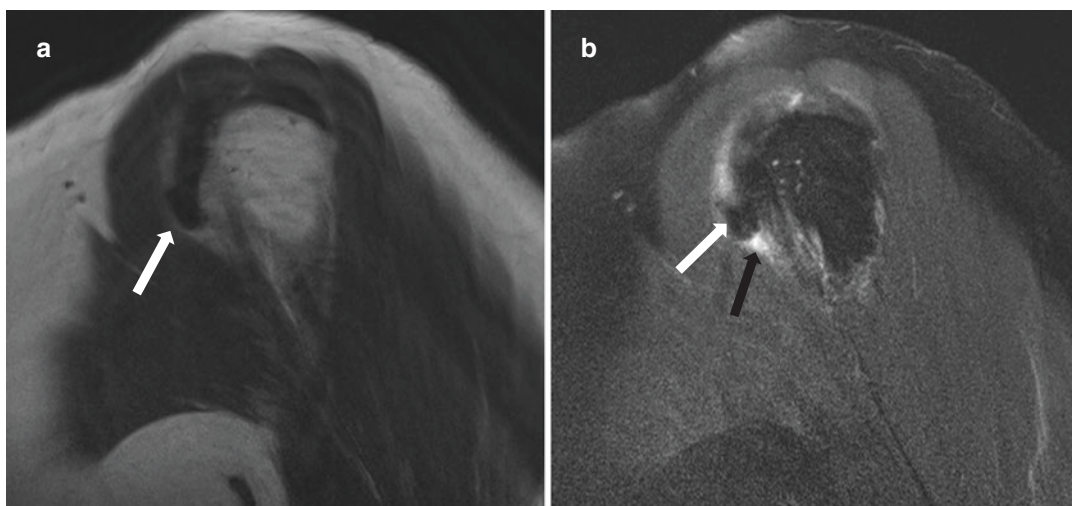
Calcific tendinitis. Sagittal oblique proton density (a) and sagittal oblique fat-suppressed, fluid-sensitive weighted (b) MR images. a demonstrates focal low signal circumscribed HAD deposits (white arrow) along the subscapularis tendon anteriorly. b demonstrates
